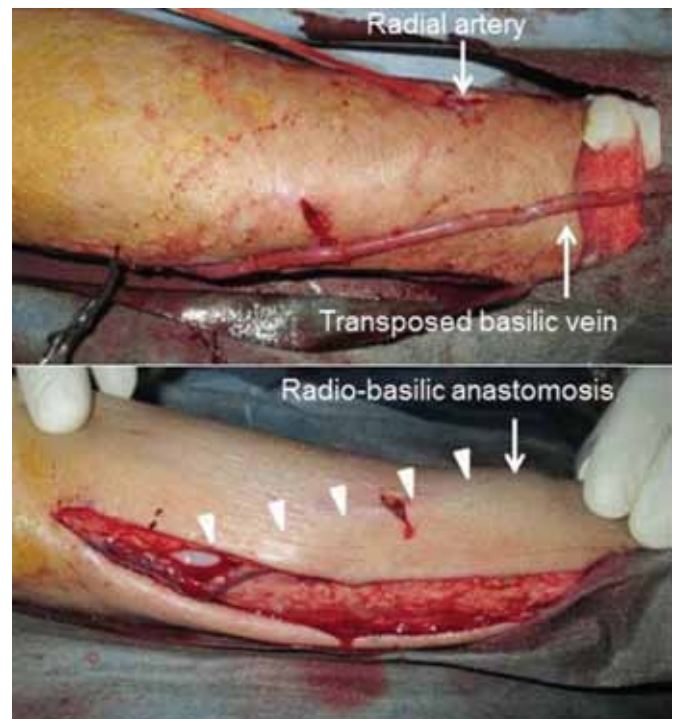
Transposed radio-basilic AVF creation (Patient 4) using selective ultrasound-guided block of the musculocutaneous nerve and the medial antebrachial cutaneous nerve. A wide skin incision was made in the anteromedial side of the forearm and the basilic vein was exposed and detached. The freed basilic vein was transposed subcutaneously (bottom panel, arrowheads) and anastomosed to the radial artery at the wrist. AVF = arteriovenous fistula; MACN = medial antebrachial cutaneous nerve; MCN = musculocutaneous nerve.
